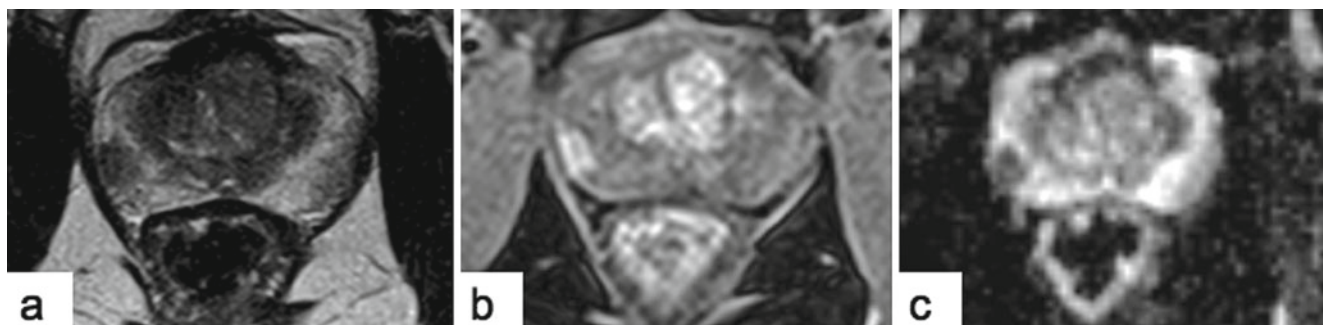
Multiparametric MRI sequences showing a right peripheral zone lesion. (a) T2-weighted. (b) Dynamic contrast-enhanced. (c) Diffusion-weighted
